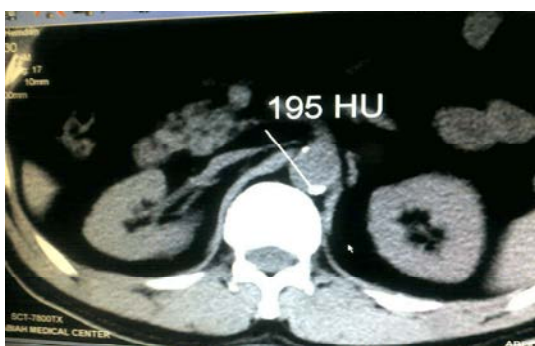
Axial CT scan of the abdominal aorta revealing calcified atheroma (195HU) grade I keeping with mild degree calcification.
